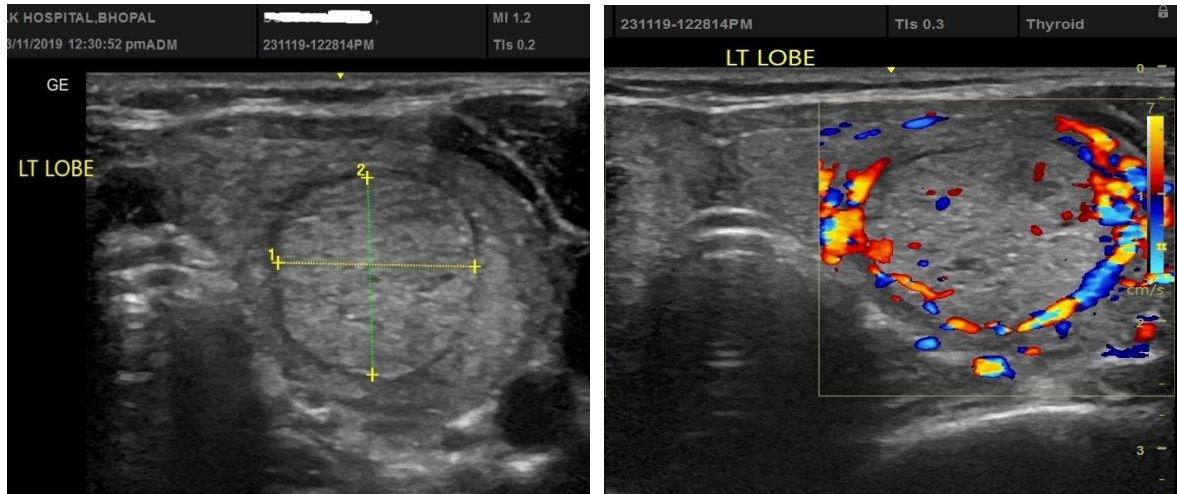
follicular adenoma(a)Gray scale HRSG showing hyperechoic, predominantly solid, wider than tall lesion with peripheral halo in left lobe of thyroid (b)Doppler USG shows peripheral vascularity.
